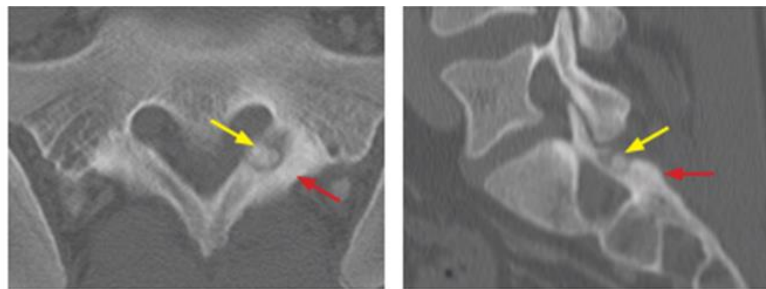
CT Scan Image of Osteoid Osteoma
